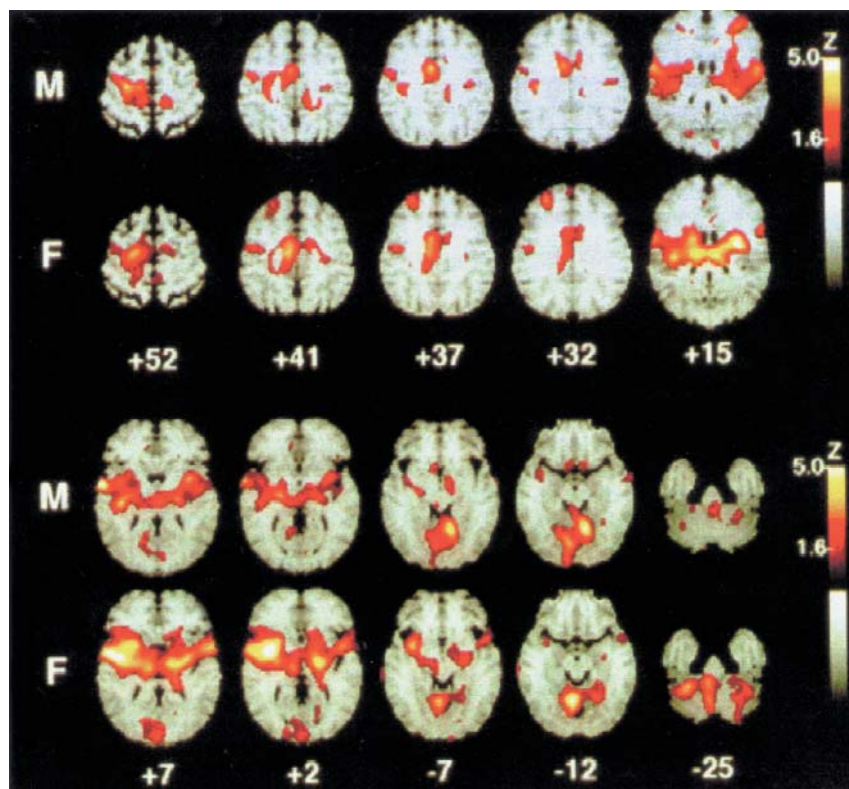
Statistical map of regional cerebral blood flow responses of 10 males (M) and 10 females (F) to repetitive noxious heat stimulation (50 °C) of the left volar forearm. Color coding of Z scores as indicated by flame bar at right. The right hemisphere of the MRI stereotactic template is on the reader's left. The numbers below columns of images indicate millimeters above a plane connecting the anterior and posterior commissures. Significant activations occur in the contralateral cingulate cortex (+41, +37), premotor, and insular cortex (+15, +7), ipsilateral insula (+7, +15), and bilateral cerebellar
